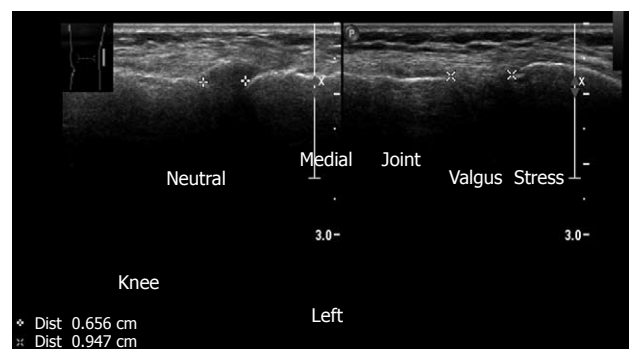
Left knee medial aspect. Ultrasound demonstrates medial collateral ligament. Joint space is normal. Neutral position. Joint space measures 0.656 cm. The same area under valgus stress, demonstrating joint space of 0.947 cm, pointing to medial collateral ligament insufficiency, clinically manifested by mild knee instability.
